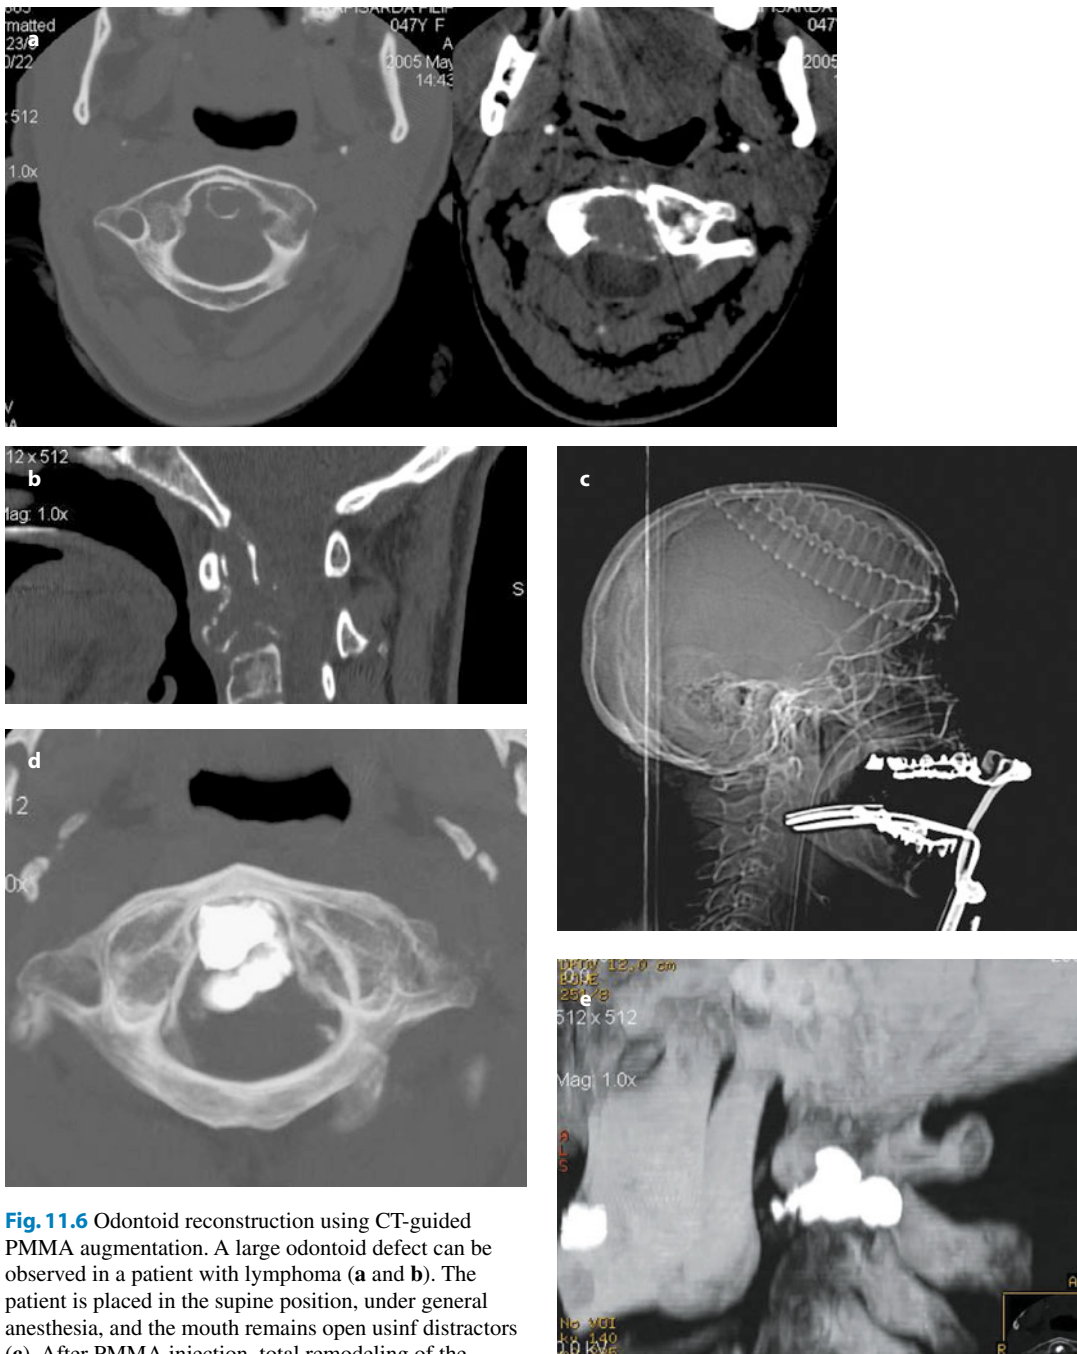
Odontoid reconstruction using CT-guided PMMA augmentation. A large odontoid defect can be observed in a patient with lymphoma (a and b). The patient is placed in the supine position, under general anesthesia, and the mouth remains open using distractors (c). After PMMA injection, total remodeling of the odontoid process recreating the C1–C2 articulation is demonstrated (d and e)
